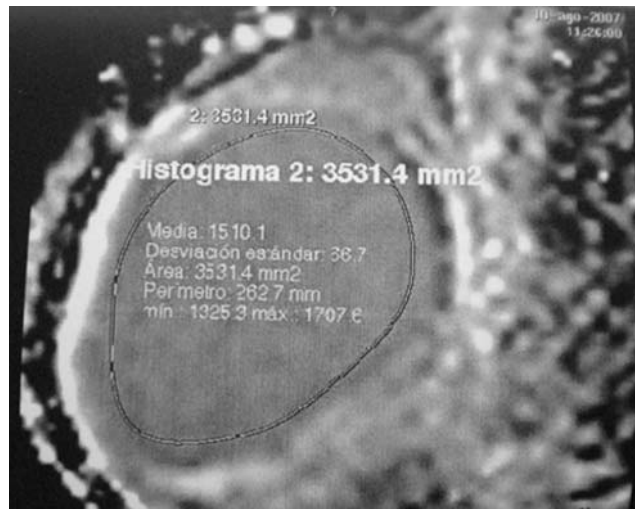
Magnetic resonance imaging study
